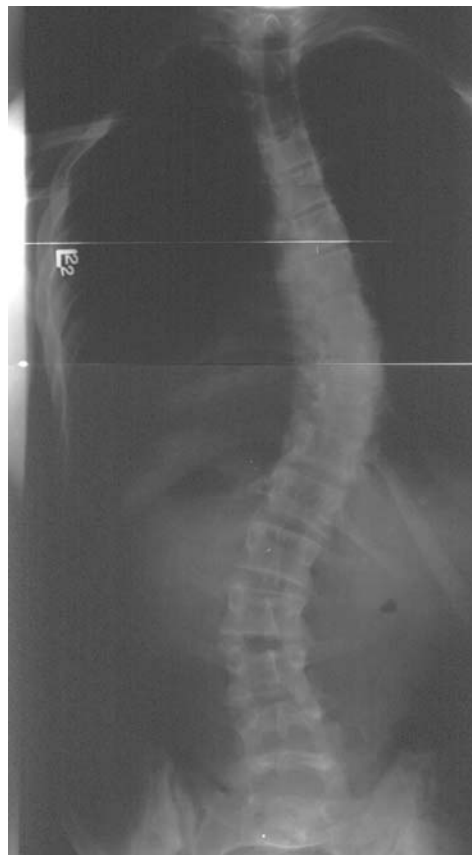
Posteroanterior radiograph of the spine in a patient with a double spinal curve. Double curve: right thoracic curve, T5-12 with a degree of curvature of 45; left lumbar curve, T12-L4 with a degree of curvature of 35.
